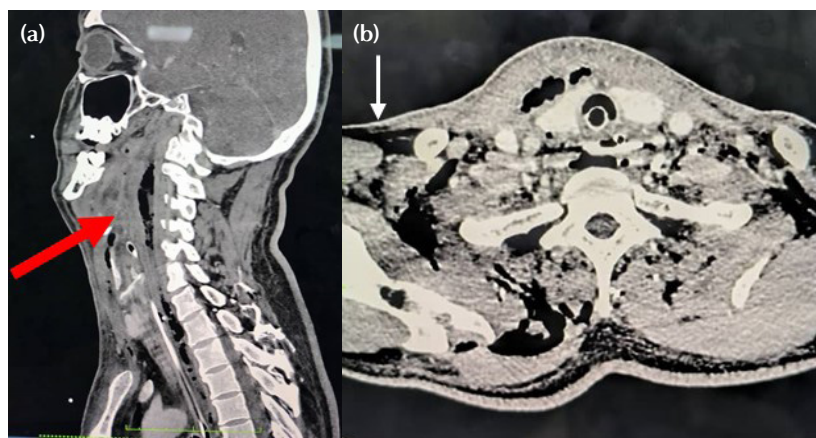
(a) Initial computed tomography neck showed extensive multiloculated gas containing collection seen at retropharyngeal region (red arrow) from the level of oropharynx in sagittal section; (b) and right anterior cervical space (white arrow) in axial section
